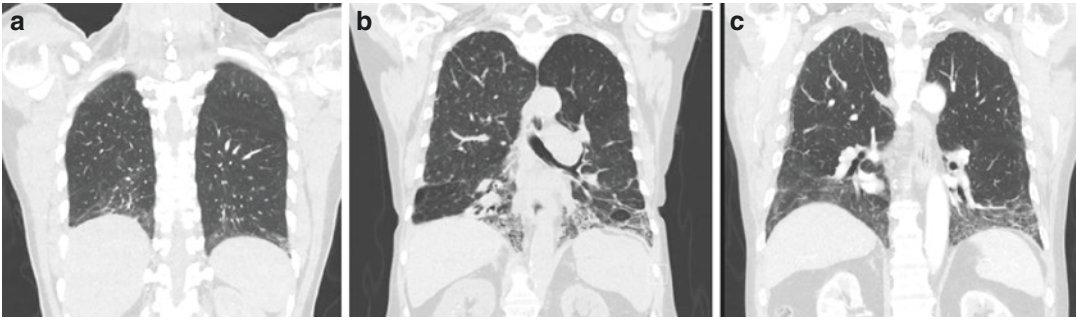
Common CT image findings in myositis-associated ILD including basilar predominance with variable ground glass opacities and reticulation. (a–c) Coronal sections from three different patients with myositis-associated ILD
